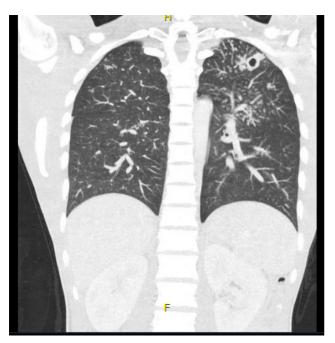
Chest CT showing cavitation at the left upper pulmonary lobe.
